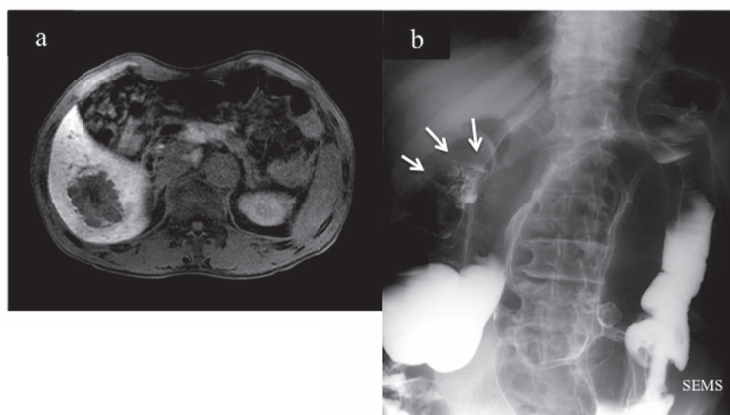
The patient with synchronous liver metastasis and proximal colon cancer. (A) The synchronous liver metastasis located in the right lateral segment was identified on Gd-EOB-DTPA MRI (EOB-MRI). (B) In the patient with obstructive descending colon cancer, the synchronous colon cancer located on the hepatic flexure (white arrows) was identified by gastrografin enema.
